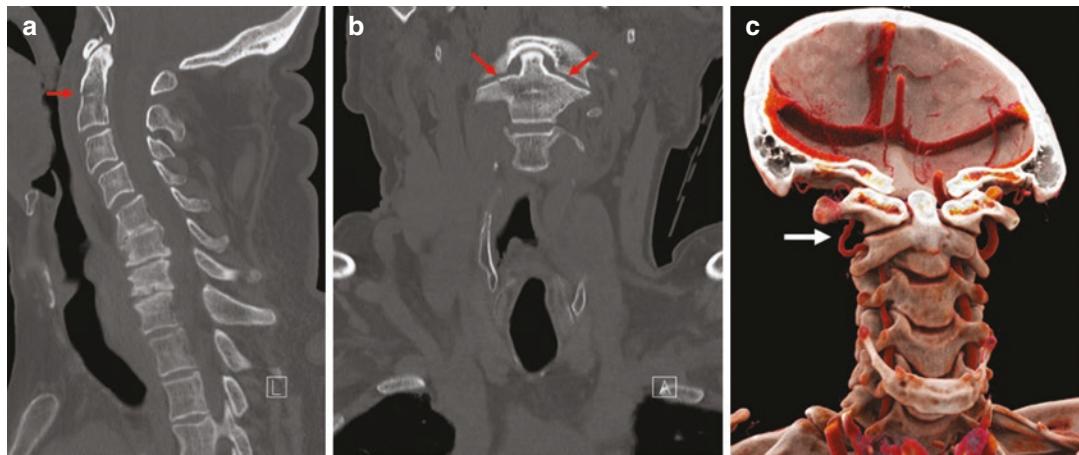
A 60-year-old man fell down the stairs while drunk. (a) Sagittal (b) coronal CT cervical spine images show a non-displaced Type 3 non-displaced odontoid process fracture. (c) Cinematic-rendered image (different
